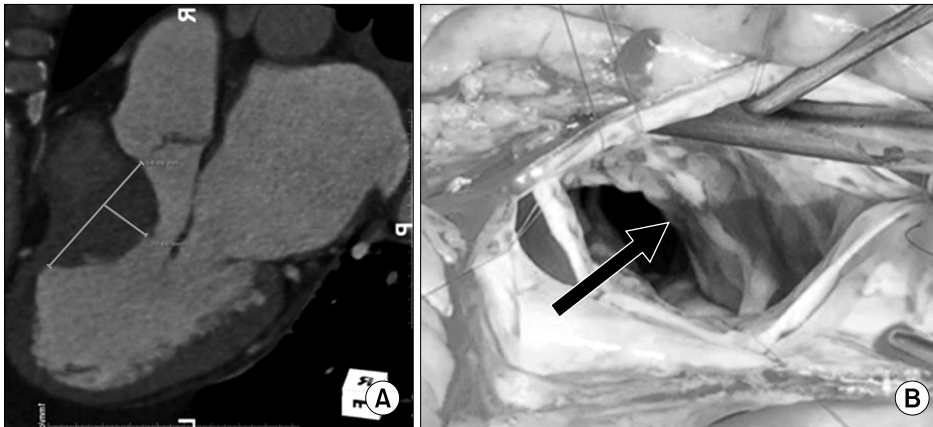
(A) Measurement of the depth and length of the muscle targeted for resection on the heart computed tomogram. (B) Operative photo showing the hypertrophied septal muscle (arrow).
